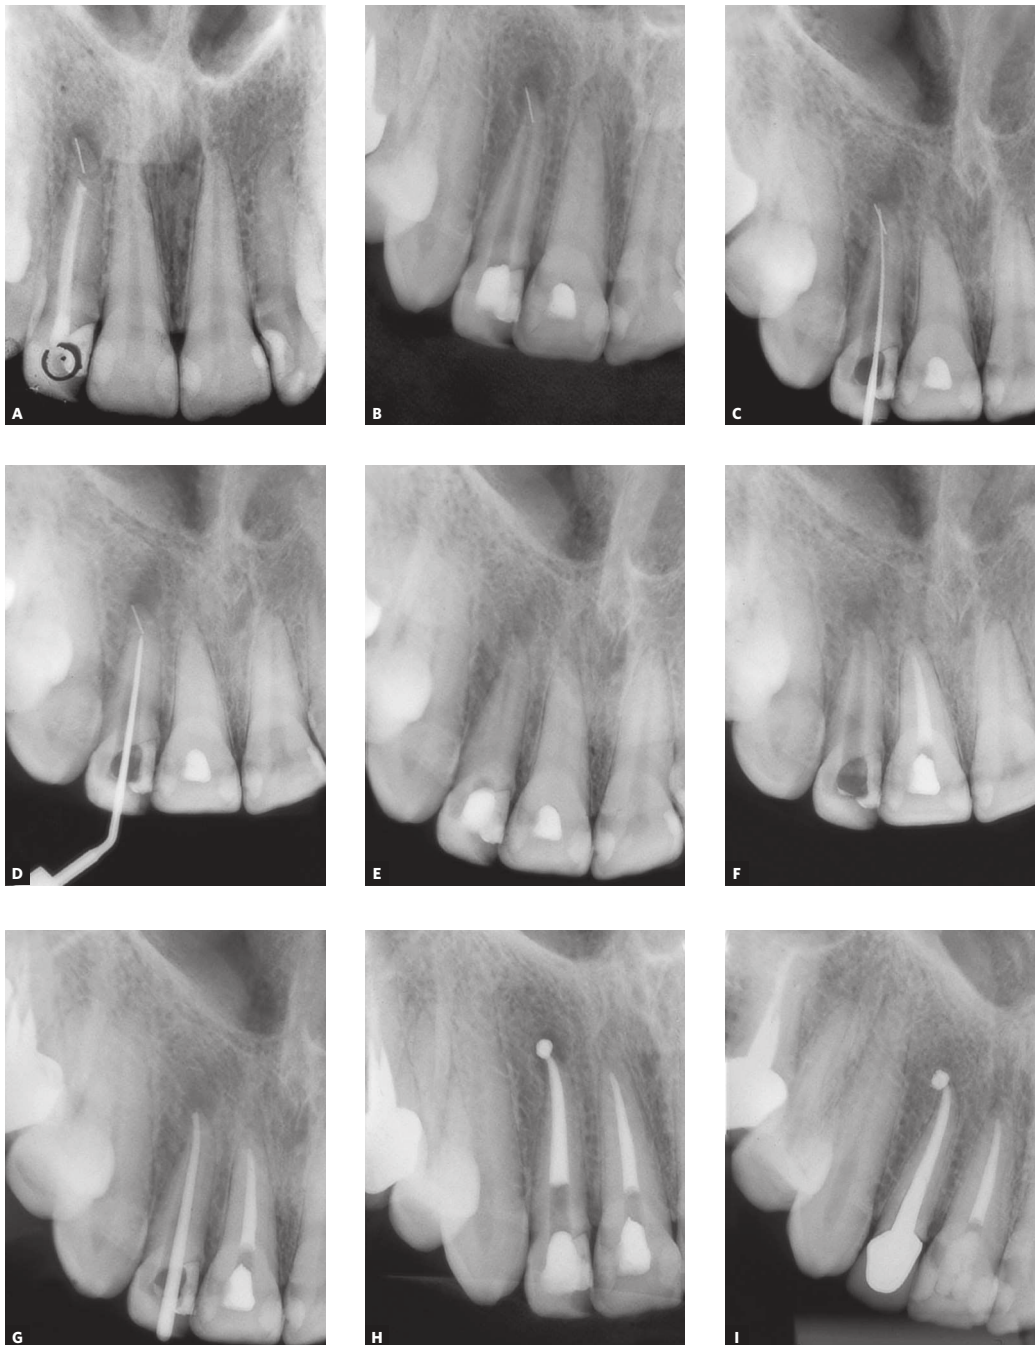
A) Baseline radiograph shows broken metal file in apical third of root; B) Removal of obturation material; C) Broken fragment bypassed by K-file #15; D) Multisonic-S A90 ultrasonic tip; E) Broken fragment moved past root apex after ultrasound was used; F) Removal of metal fragment; G) Cone fit; H) Final radiograph; I) Four-year follow-up.
